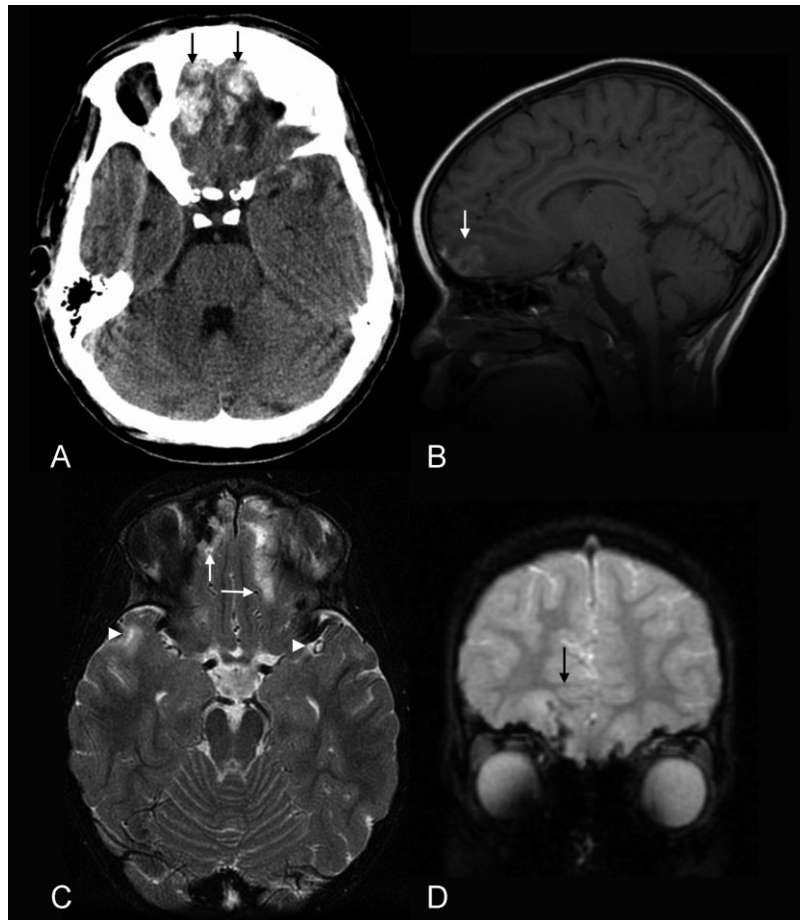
Computed tomography and magnetic resonance imaging of a cortical contusion. (A) The axial computed tomography image demonstrates high attenuation within the gyral crests of the bilateral orbitofrontal lobes (arrows). Partial volume artifact and streak artifact in this area are particularly problematic on computed tomography. (B) The sagittal T1-weighted image demonstrates abnormal increased signal intensity involving the right orbitofrontal lobe (arrow). (C) The axial T2-weighted image demonstrates bilateral orbitofrontal (arrows) and temporal (arrowheads) high signal. (D) The coronal gradient-recalled-echo T2*-weighted image shows decreased signal within the right orbitofrontal lobe that is consistent with blood products (arrow).
